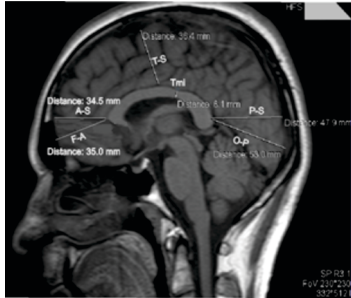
MEASUREMENT OF CORPUS CALLOSUM (MIDSAGITTAL MRI)
